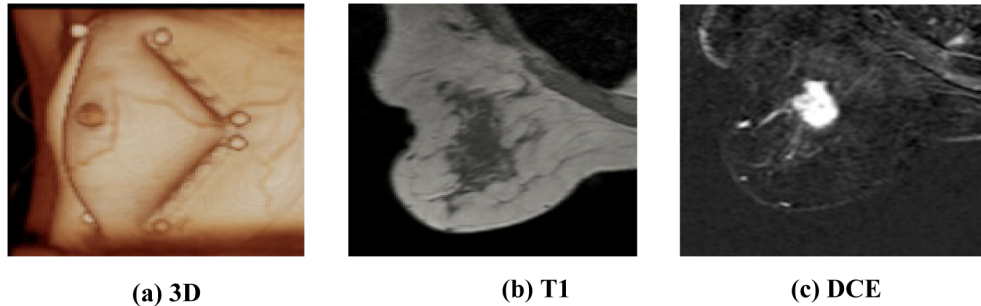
MR images from a patient with a malignant lesion ($20\text{mm} \times 27\text{mm} \times 33\text{mm}$) seen on DCE MRI. (a): Screenshot of the Nirview 3D surface rendering of the T1 MRI. Fiducial markers and fiber bundle positions are shown; (b): Standard T1 image; and (c): Dynamic contrast-enhanced MRI.
